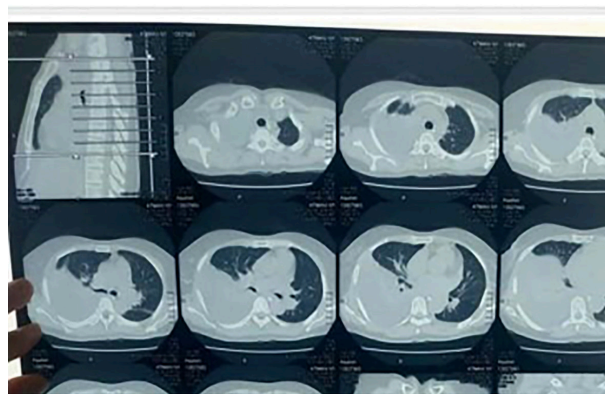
Thorax CT scan (First Admission).
